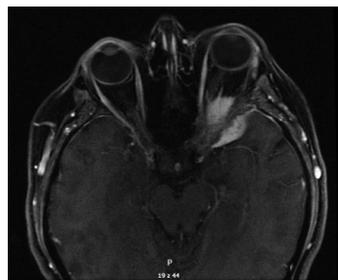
Magnetic resonance imaging of orbit (axial Lava Flex sequence) showing meningioma extending to the orbit and intracranial infiltrate with a thickening of the adjacent bone structure. Courtesy of the Department of Diagnostic Imaging, University Hospital in Krakow
